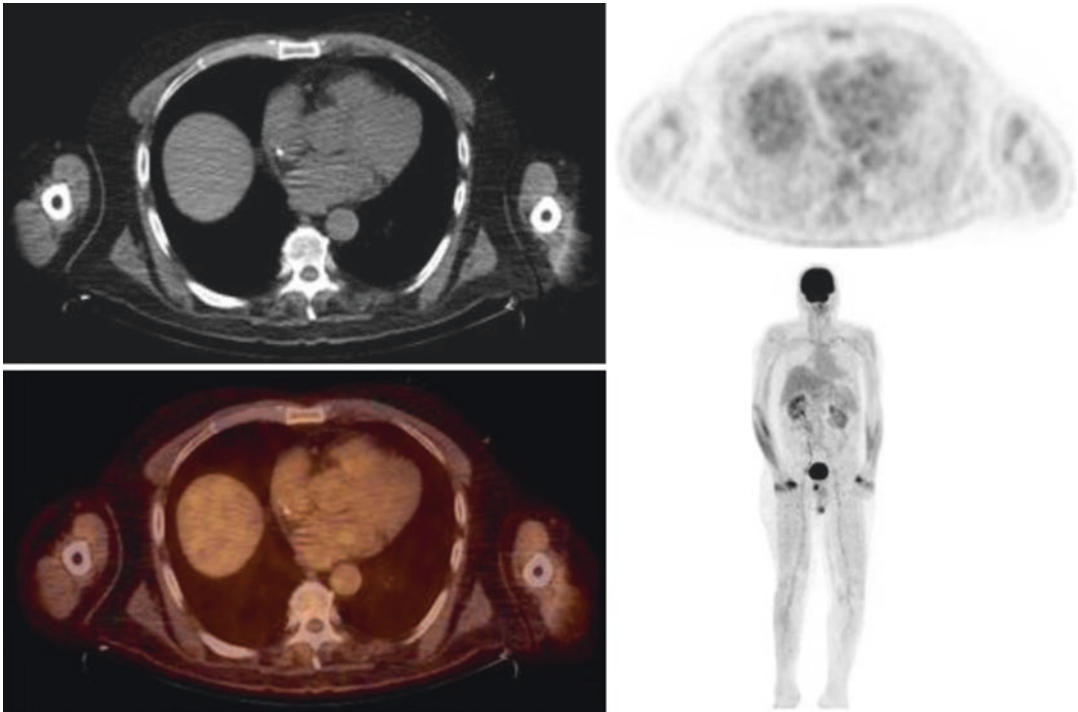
A 64-year-old male with a history of lymphoma. PET/CT images demonstrate a normal distribution of radiotracer. Note physiologic activity in the forearm muscles and excretion of the FDG by the kidneys and urinary bladder
